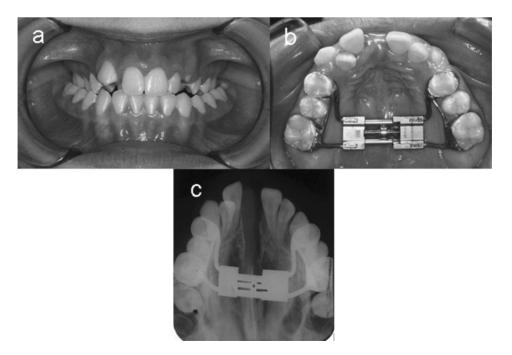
A female patient aged 13 years. (a) Intra-oral view before rapid maxillary expansion. (b) Memory palatal split screw on the expanded maxillary arch. (c) Occlusal radiographic view of the hard palate after expansion.
